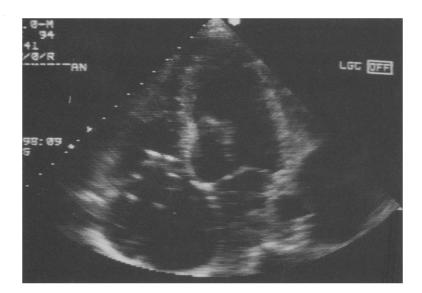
Echocardiographic scan clearly shows filter prongs across tricuspid valve.
